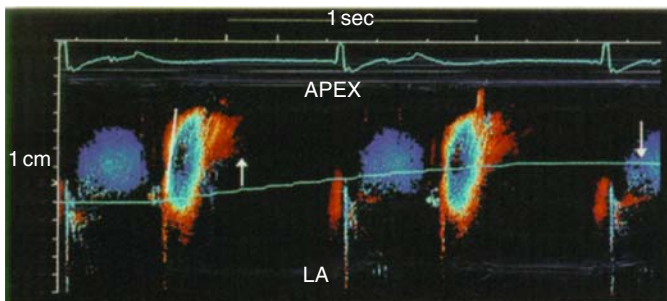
Color M-mode Doppler from left atrium toward the ventricular apex, comparing constrictive pericarditis (top) in which flow is rapid, and restrictive cardiomyopathy (bottom) in which it is slow. Isovolumic flow in restriction is rapid (yellow line).
